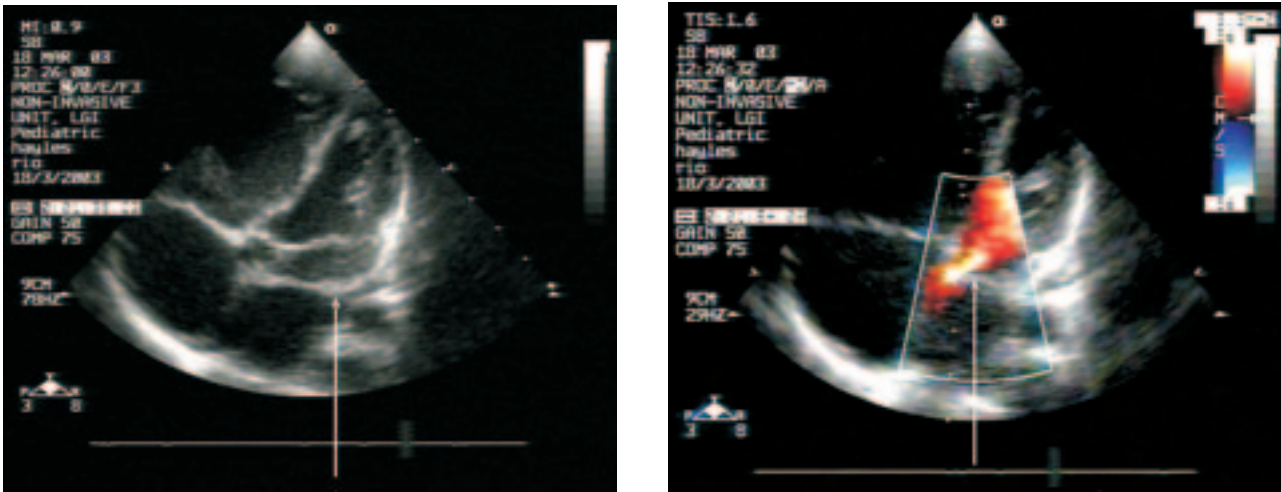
A: Preoperative echocardiography demonstrating the *cor triatriatum*. The arrow indicates the membrane dividing the left atrium into two chambers. B: Preoperative Doppler echocardiography demonstrating the *cor triatriatum*. The arrow indicates blood flow through the narrow orifice in the atrium.
